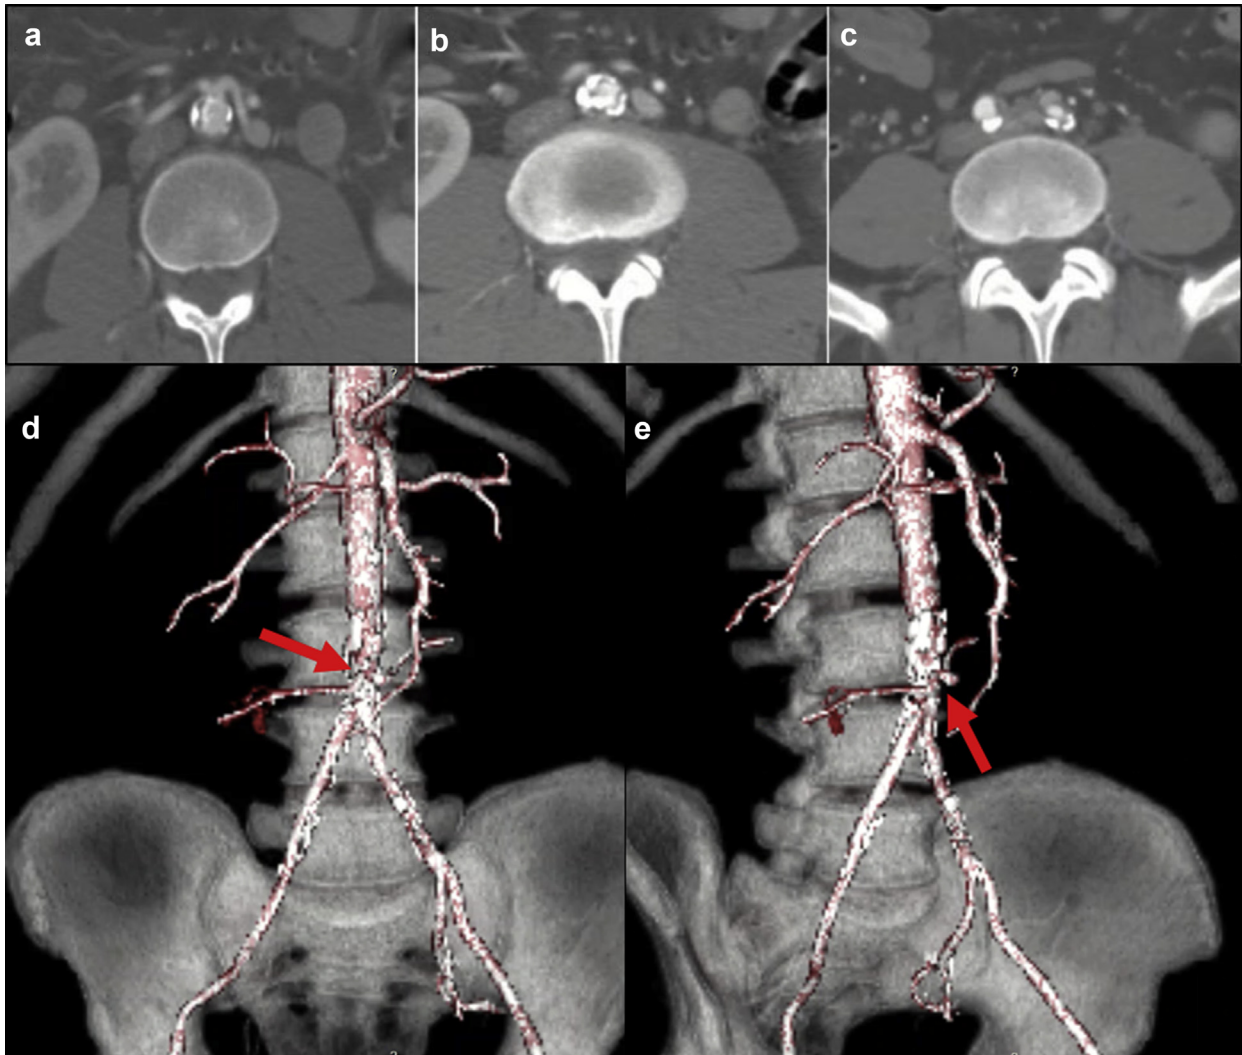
a-c, Preoperative computed tomography scan demonstrating calcifications beginning proximally at (a) accessory renal artery (ARA) origin and extending distally into (b) aorta and (c) aortic bifurcations. d and e, Three-dimensional reconstructed computed tomography images; the arrows indicate ARA origin in (d) anteroposterior and (e) anterolateral views.
